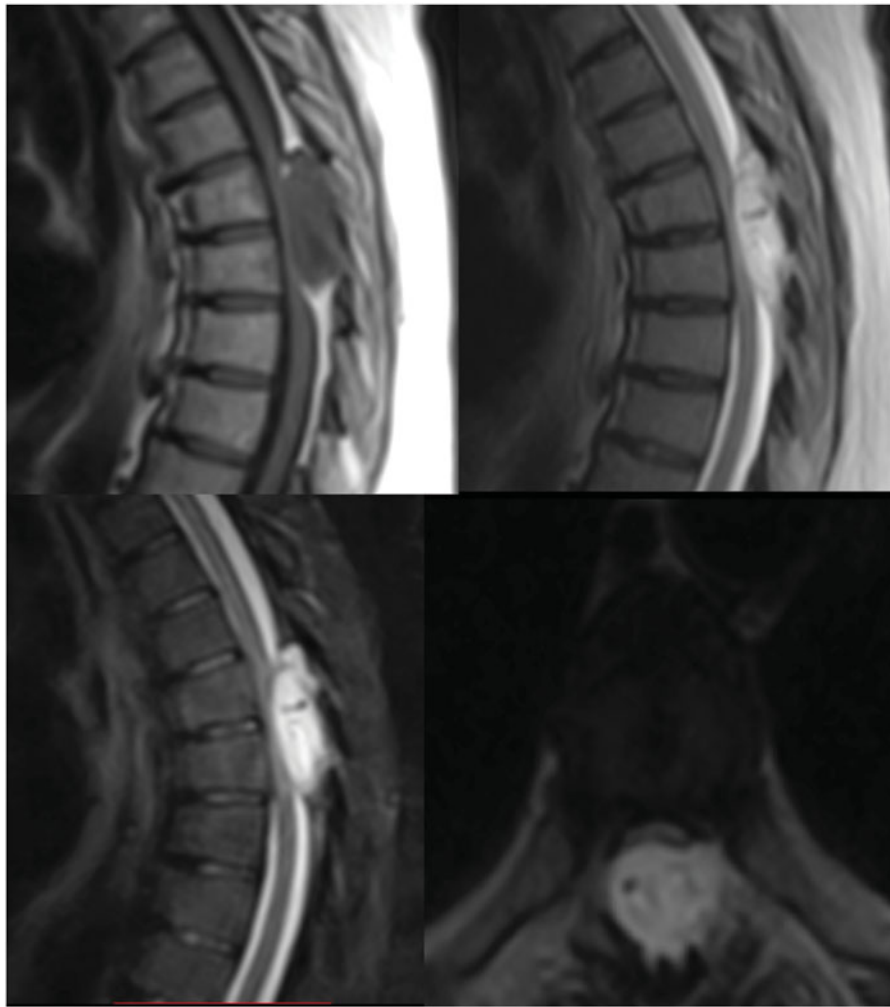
MRI appearance of an epidural capillary hemangioma: hypointense on T1-weighted, hyperintense on T2 weighted and enhancement with gadolinium.
